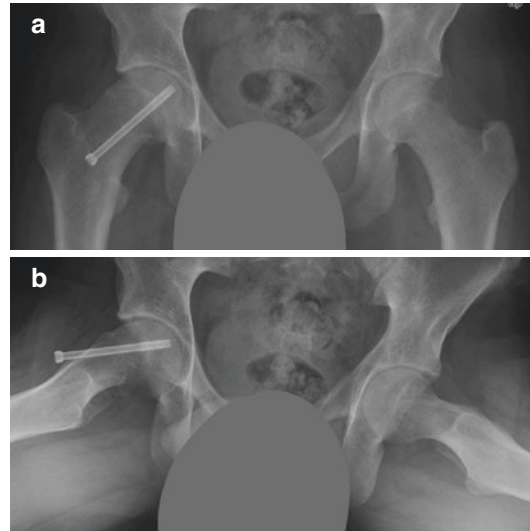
Fixation of a chronic slip of the right hip using a screw. The screw should be centrally located on the antero-posterior (a) as well as on the frog-leg lateral X-ray (b). The screw has to be inserted into the anterior side of the femoral neck because the epiphysis has glided posteriorly
